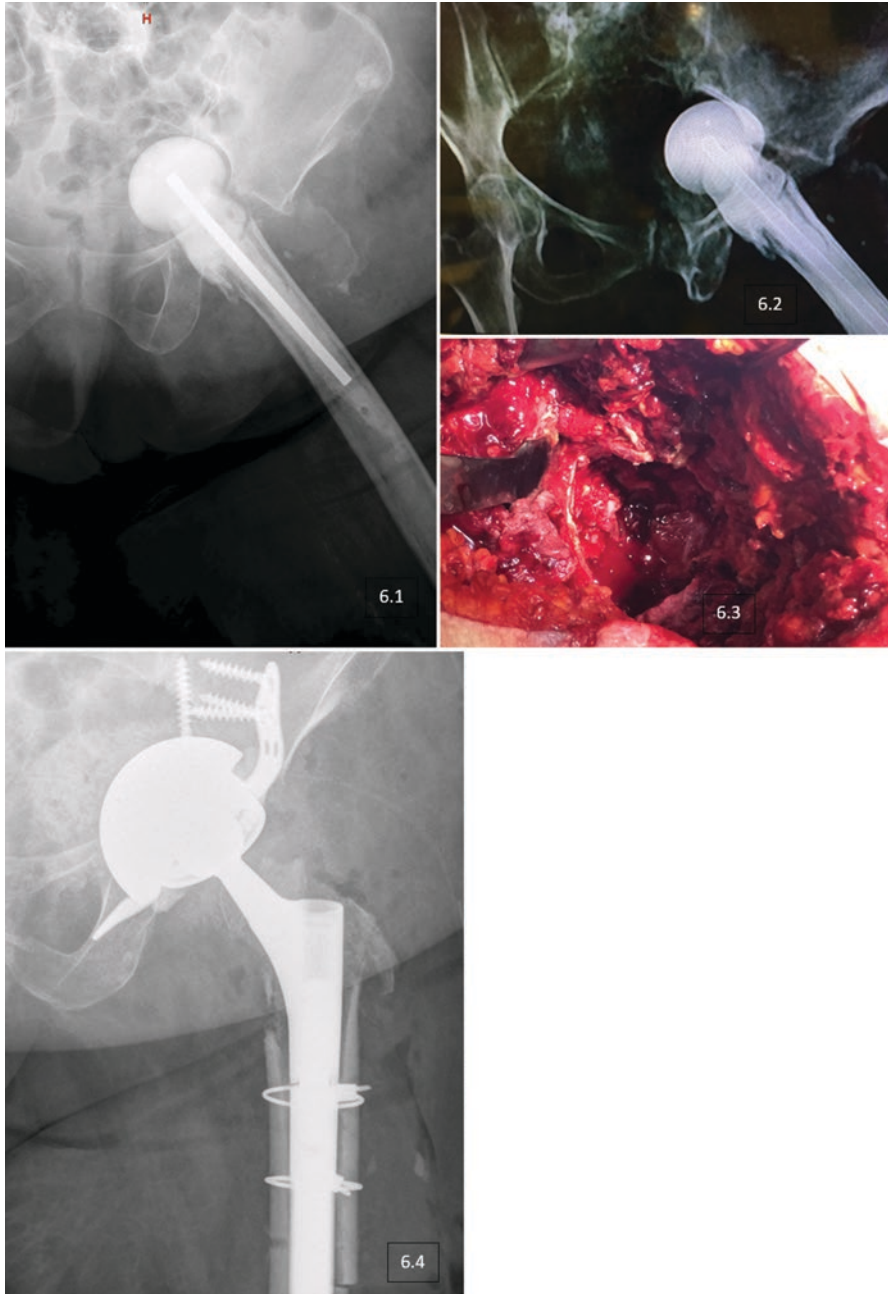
6.1 and 6.2: Intrapelvic spacer. Acetabular defects Paprosky type IIIB with pelvic discontinuity. 6.3: Intraoperative view 6.4: Postoperative radiograph reconstruction with trabecular metal and cup-cage
